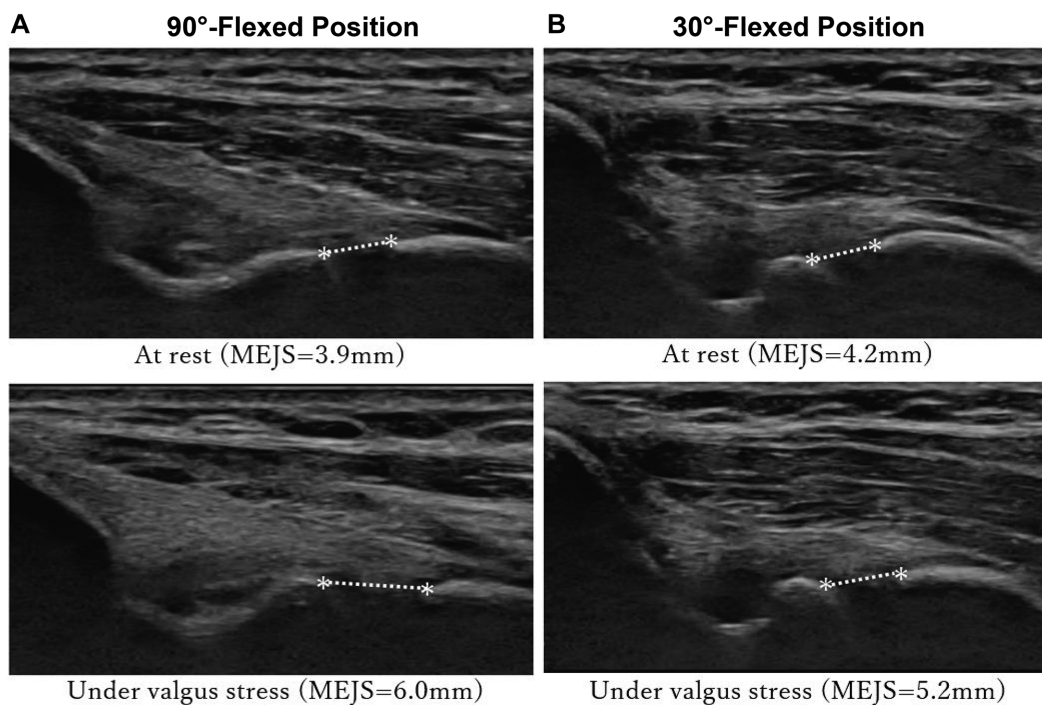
Ultrasound images from a 19-year-old pitcher showing the medial elbow joint space (MEJS; represented by asterisks) on the throwing side for the (A) 90° of flexion and (B) 30° of flexion positions. Valgus laxity was greater at the 90° of flexion position than at the 30° of flexion position (2.1 vs 1.0 mm).
